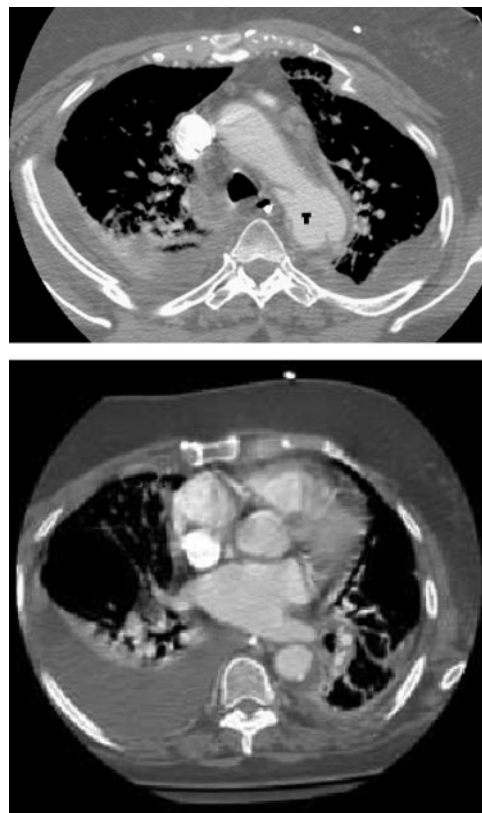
Traumatic aortic rupture secondary to a motor vehicle crash. Top, Axial CT image demonstrates a traumatic injury with pseudoaneurysm (T) in the proximal descending thoracic aorta, numerous bilateral rib fractures, and small bilateral pleural effusions, with no significant mediastinal hematoma. Bottom, Still image through the thorax further demonstrates the extent of the aortic trauma. The full cine video for the bottom panel is available in the online-only Data Supplement at <http://circ.ahajournals.org/cgi/content/full/CIR.0b13e3181d4739e/DC1>. CT indicates computed tomographic imaging.
